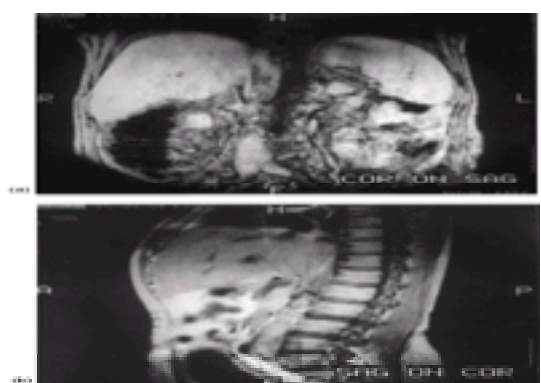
(a and b) Magnetic resonance imaging, showing complete thrombosis of the hepatic and abdominal inferior vena cava of a patient with Budd–Chiari syndrome
